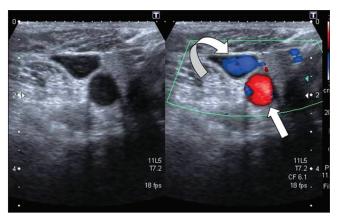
Intra-operative ultrasound using high frequency probe in short axis view revealed anechoic thrombus free lumen of right internal jugular vein
